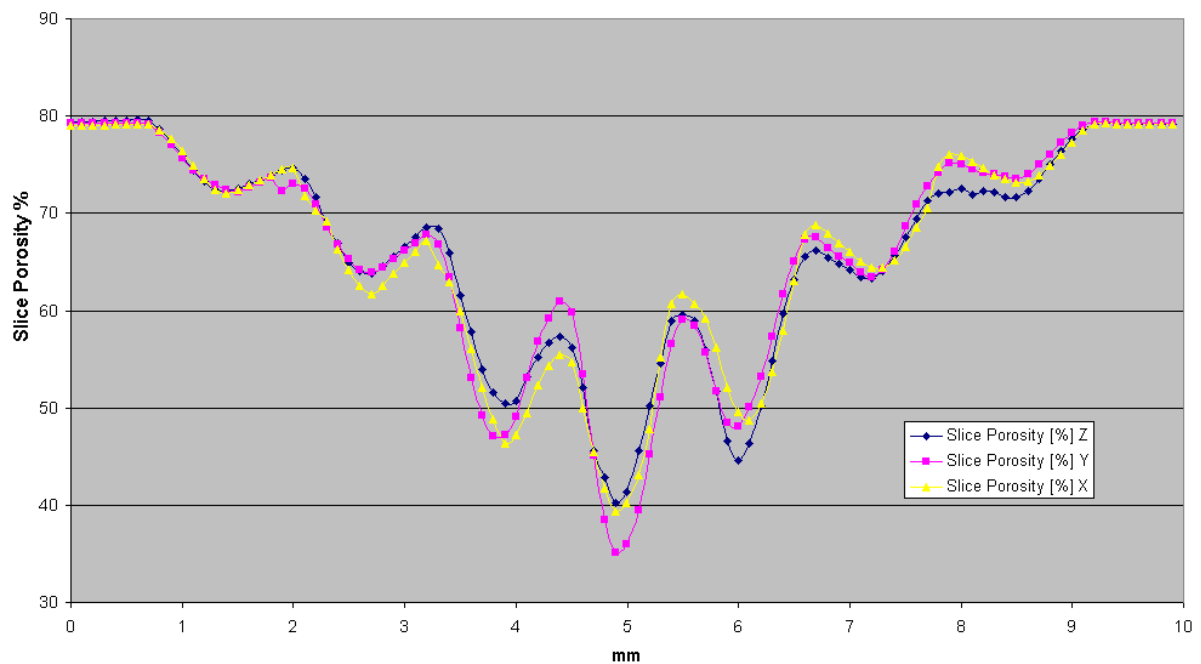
shows the distributions of sliced area along the *X*, *Y* and *Z* axes. The same axis system used for the cubic  $\mu$ CT sample was adopted for the cubic ADI samples, in order to compare the two structures. However, several relative orientations of the cubes were possible.
